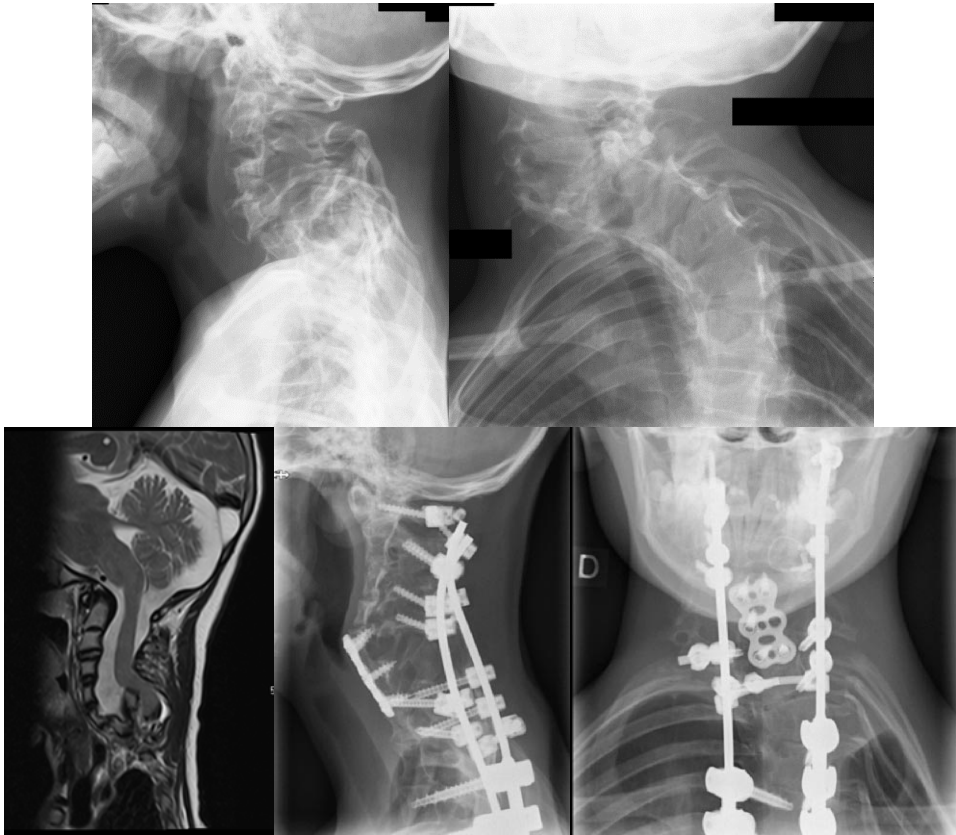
Instrumented cervical spinal fusion, non-OC fusion: Figs. 6-A to 6-H. 10-year-old boy with C6-C7 rotational luxation and proximal thoracic scoliosis and type I neurofibromatosis. Preoperative cervical radiographs (A-C) and MRI (D) demonstrate C6-C7 rotational luxation and proximal thoracic scoliosis. Treated with posterior C1-Th9 fusion and decompression of C5-C6 to C7-Th1 and anterior C7 corpectomy. At three-year FU standing radiographs (E-H) demonstrate union, and patient participates in school physical education without symptoms.
